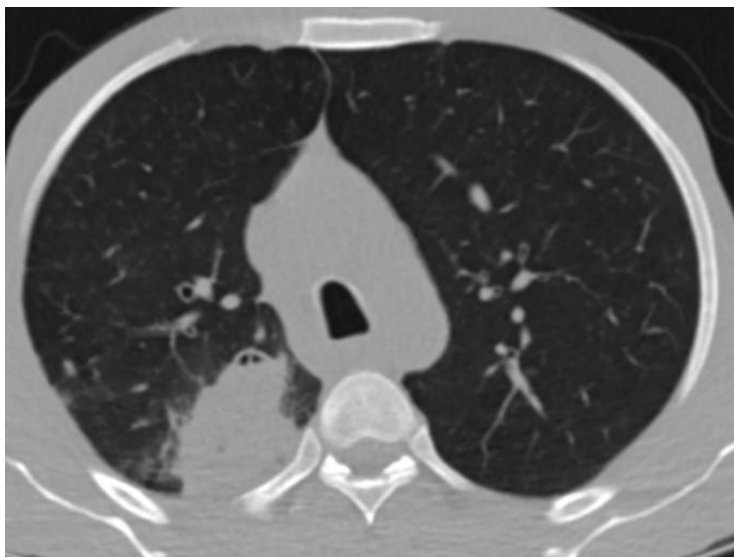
On computed tomography (CT), a large heterogeneous mass of 5.4 × 6.3 × cm, covering the upper region of the right hemithorax, with rough edges and poor borders.
